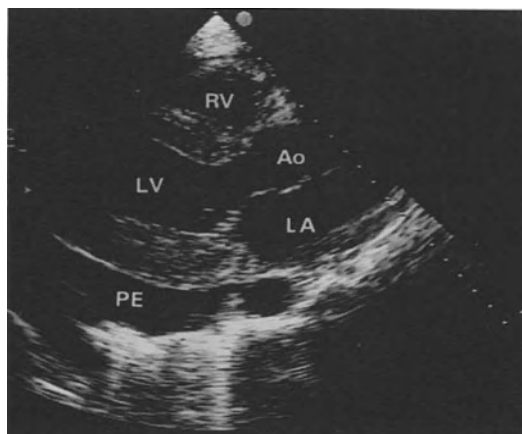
2D echocardiogram (parasternal long axis view) showing pericardial effusion (PE) behind the left atrium (LA).
